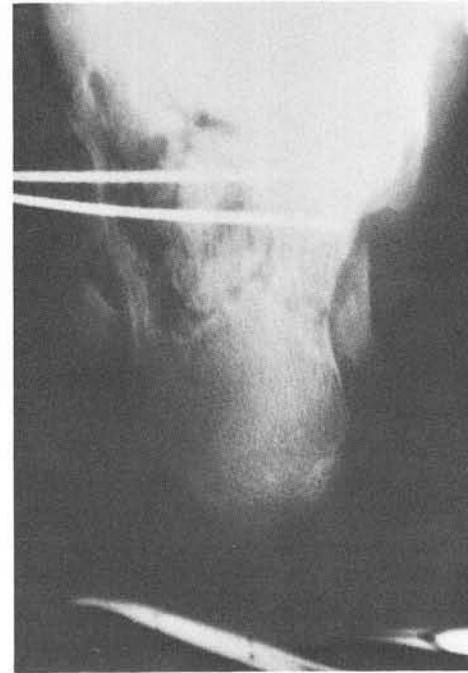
Intra-operative radiographs verify restoration of normal facet patterns. 0.062 K-wires also acts to provide a guide for placement of permanent fixation.
